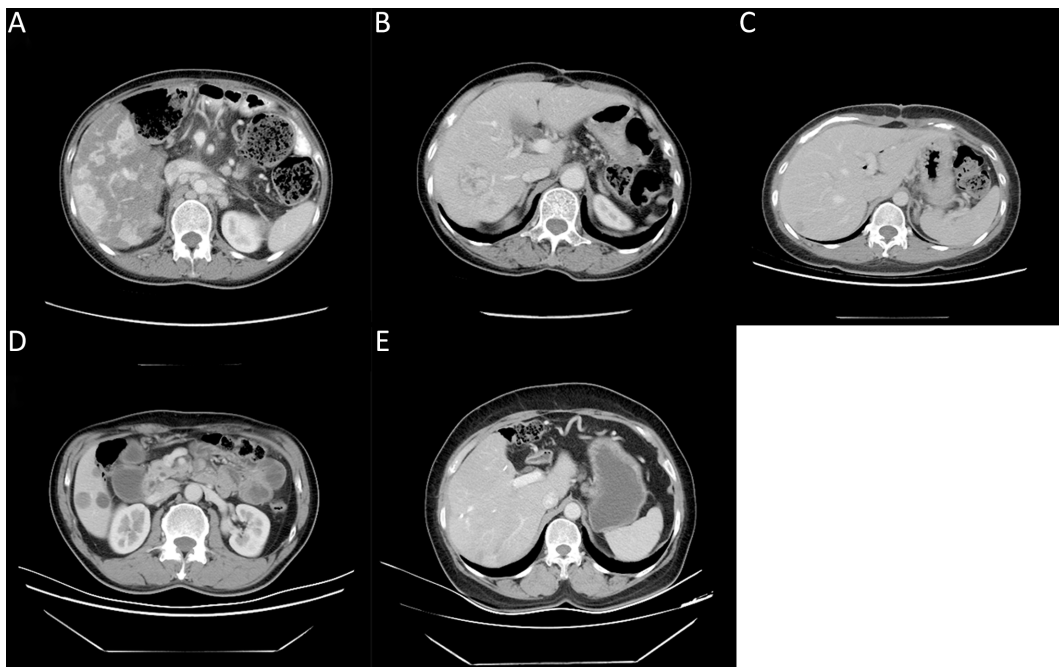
Examples of some radiological features seen on pre-treatment CECT of qualitative enhancement measurements. (A) Low enhancement; (B) High enhancement; (C) Heterogeneous enhancement; (D) Well-defined margins; (E) Poorly-defined margins. CECT, contrast-enhanced computed tomography.
